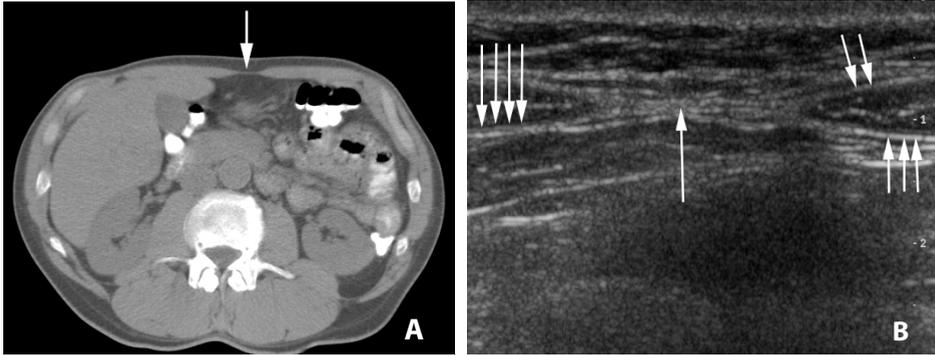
(A) Preoperative CT scan of a 55-year-old male shows the anatomy of the ventral abdominal wall and the linea alba (arrow) on the midline. On both sides of the linea alba are the rectus muscles. (B) Preoperative transverse sonogram shows the linea alba (arrow) on the midline. On both sides of the linea alba are the rectus muscles with anterior rectus fascia (two arrows). The peritoneum is marked with triple arrows, and immediately in front of the peritoneum is the posterior rectus fascia, a thinner line marked with four arrows.
